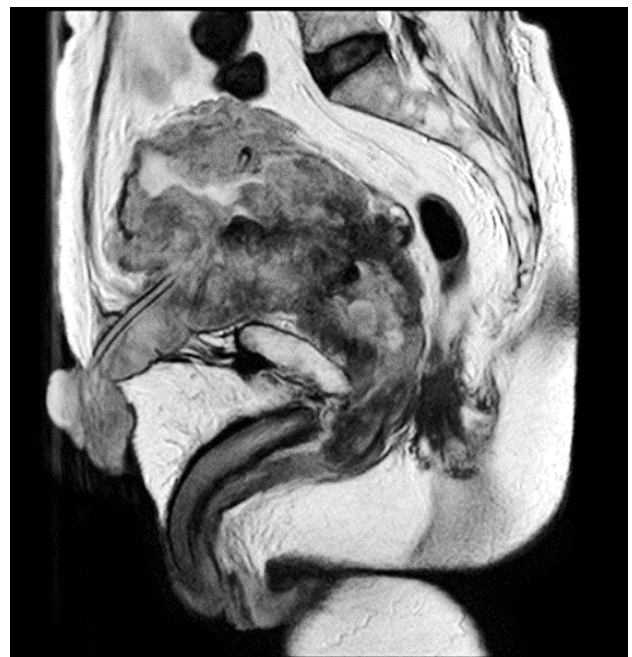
MRI pelvis T2 weighted image (sagittal section) showing lesion extending from the prostate along the anterior abdominal wall and through the SPC site.
